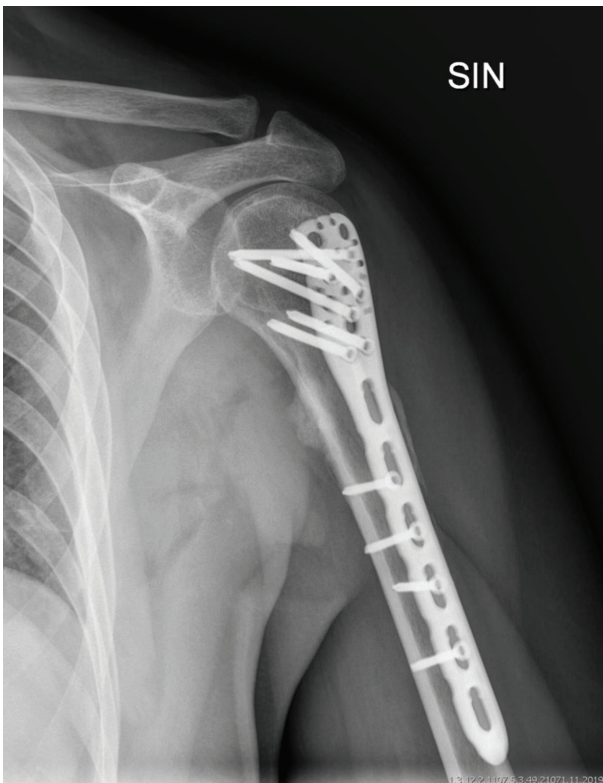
One year follow up x-ray
